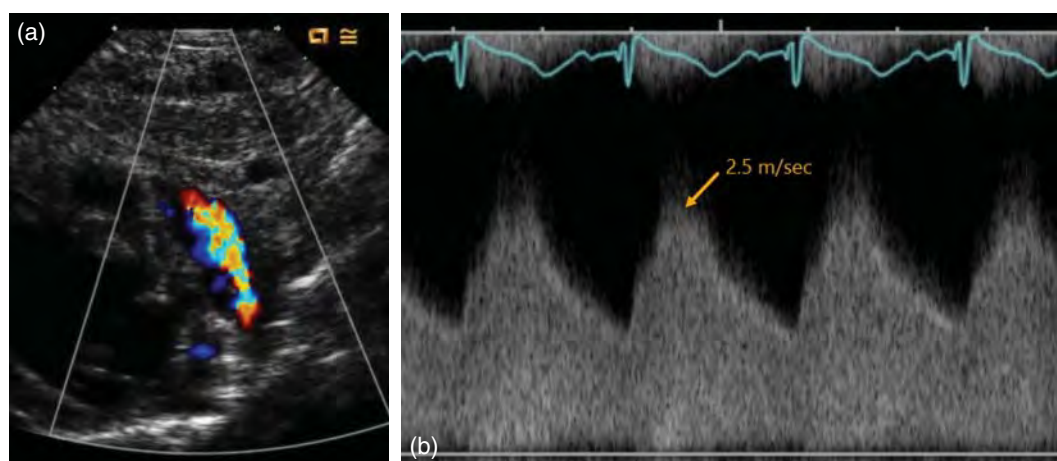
(a) Neonate with a small PDA and normal pulmonary resistance. (b) Spectral Doppler image demonstrates a continuous left to right shunt (from aorta to pulmonary artery). The peak flow occurs during systole.
